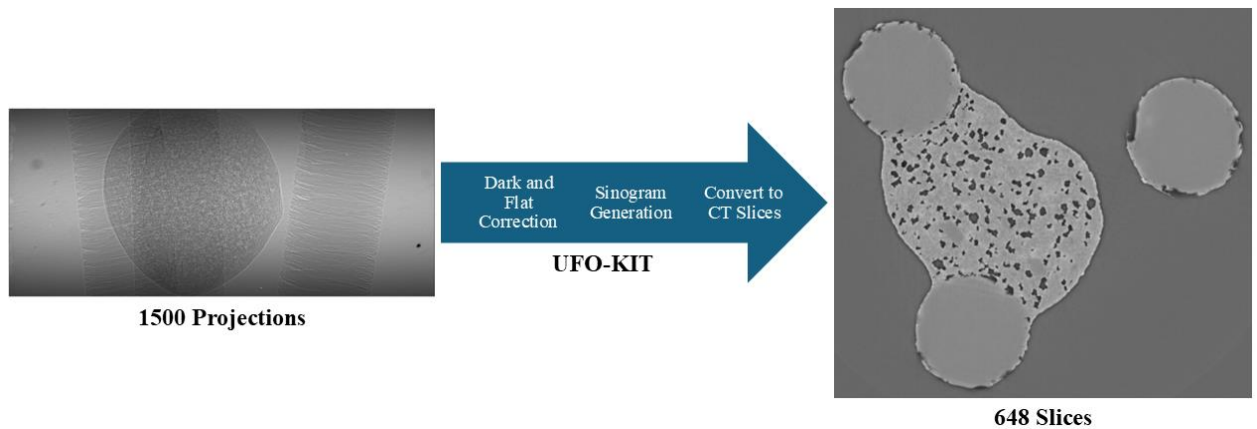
Example of the CT reconstruction process using the collected X-ray projections for 80LMH20APAP sample.
